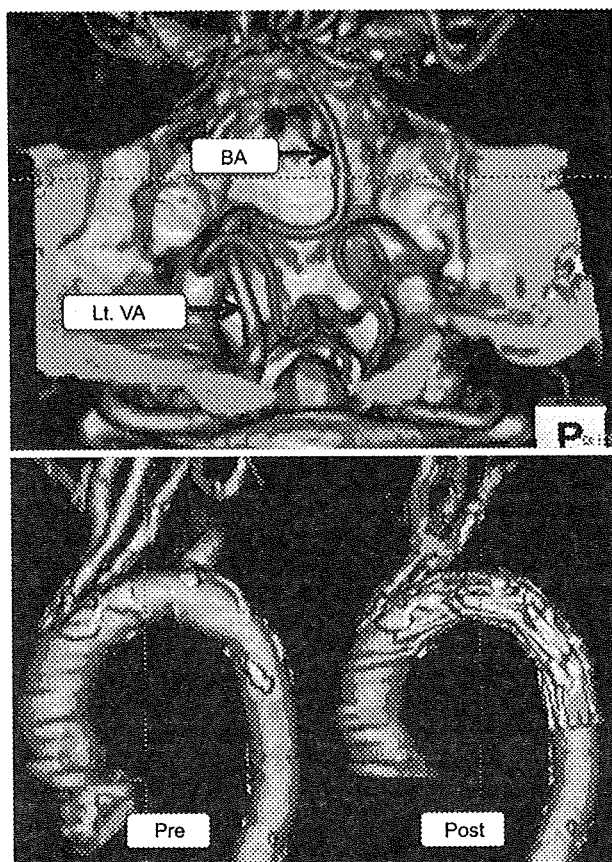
CTA images. CTA of the vertebro-basilar artery suggested terminated right VA (upper). A fenestrated stent graft well preserved antegrade blood flow into LSA as well as LCC (lower). Lt. VA, left vertebral artery; BA, basilar artery.
